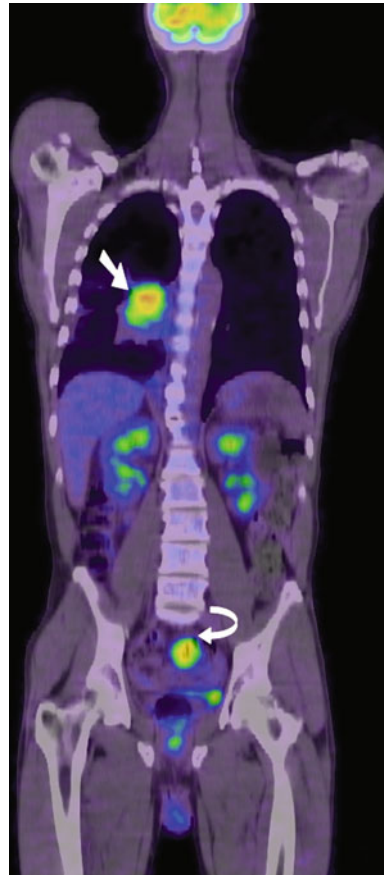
A 58-year-old man with newly diagnosed non-small cell lung cancer underwent a staging PET-CT scan. The known primary malignancy at the right pulmonary hilum demonstrated intense focal FDG uptake (*arrow*) with extension into the mediastinum. There was low-level ill-defined uptake surrounding this consistent with associated atelectasis. However, there was also unsuspected focal intense FDG uptake at the rectosigmoid junction (*curved arrow*) suspicious for a synchronous premalignant lesion such as a dysplastic polyp or a colorectal cancer. There was normal urinary FDG pooling in the bladder inferior to this as well as tracer excretion in both kidneys. Colonoscopy and subsequent surgery confirmed a synchronous large circumferential moderately differentiated adenocarcinoma
